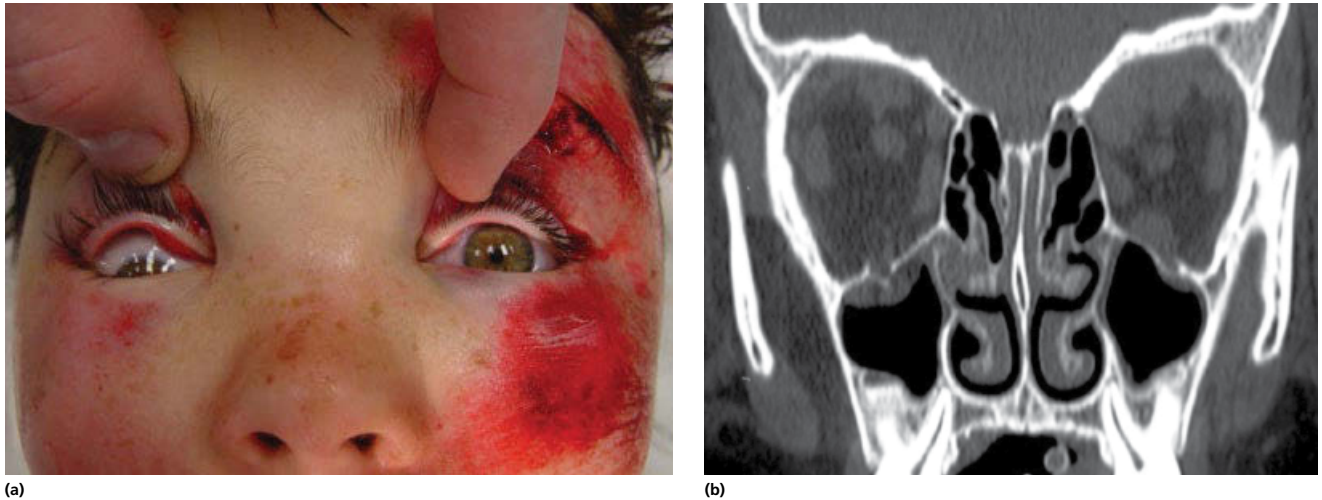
The cause of the restriction of upward gaze can be seen in the coronal CT scan: the belly of the inferior rectus muscle is pinched in a small orbital floor fracture. Early release is indicated.
